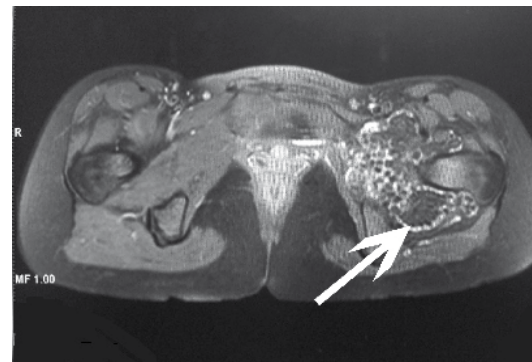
The magnetic resonance imaging shows lobulated homogenous intermediate intra-articular altered signal intensity in left hip with multiple calcified loose bodies (arrow) with post-contrast enhancement suggestive of synovial thickening.
